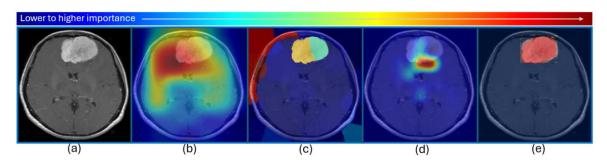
Brain MRI with tumor taken from Kaggle dataset [34] correctly classified by MobileNetV2 trained with 154 images with tumor (class 1) and 97 images without tumor (class 2) for this
